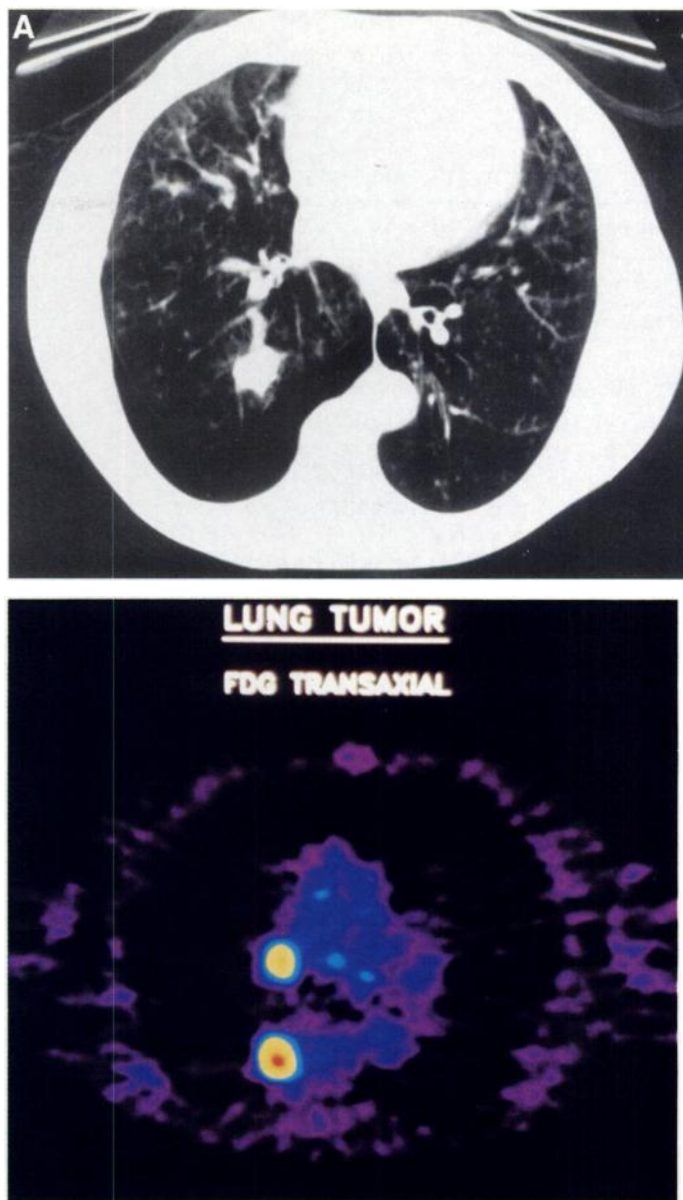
CT scan (A) from a 73-yr-old man shows a 2-cm noncalcified nodule in the right lower lobe. FDG-PET (B) study clearly shows enhanced glucose metabolism in this solitary pulmonary nodule and additionally detected a small right hilar lymph node not seen on CT, which was malignant on needle biopsy. Note pneumothorax resulting from biopsy.
